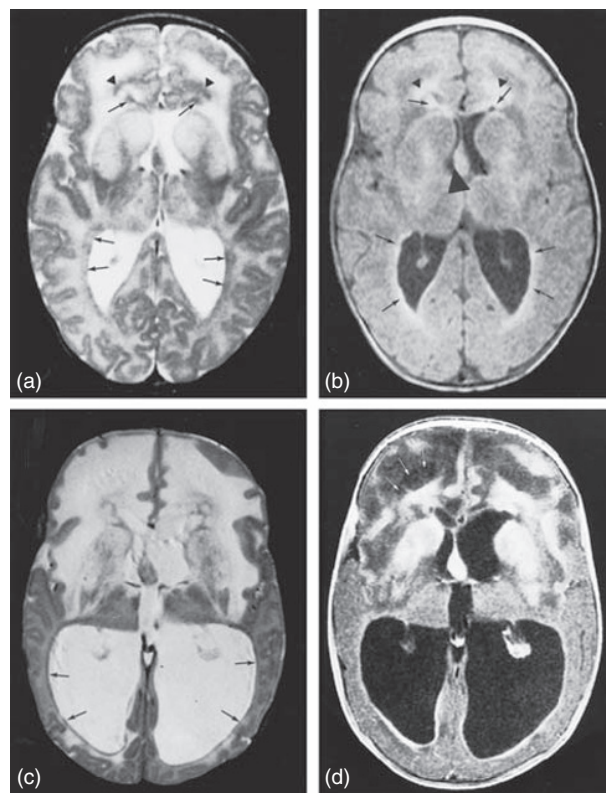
MR imaging of a patient with biopsy-confirmed infantile Alexander disease. (a and b): At the age of 1 1/2 months, the frontal white matter has a slightly higher signal intensity on T2-weighted images and slightly lower signal intensity on unenhanced T1-weighted images than does the remainder of the cerebral white matter, which has normal signal intensity for unmyelinated white matter. There is a periventricular rim of low signal intensity on T2-weighted images (arrows, a) and high signal intensity on T1-weighted images (arrows, b), with some extensions into the frontal white matter (arrowheads, a and b). The caudate nucleus and putamen have high signal intensity on T2-weighted images and are mildly swollen. (c and d): At the age of 3 months, a major increase in ventricular size is seen with extreme thinning of the posterior cerebral mantle. The frontal white matter has more abnormal signal intensity than the occipital white matter, appears markedly swollen, and shows early cystic degeneration (arrows, d). There is a thin periventricular rim of low signal intensity on T2-weighted images (arrows, c). The basal ganglia are now markedly atrophic. After contrast administration, enhancement occurs in the ventricular lining, caudate nucleus, putamen, frontal white matter, and parts of the frontal cortex (d).
